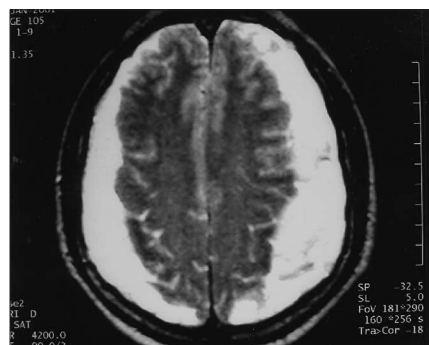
Magnetic resonance image, on admission, showing bilateral chronic subdural haematomas.
